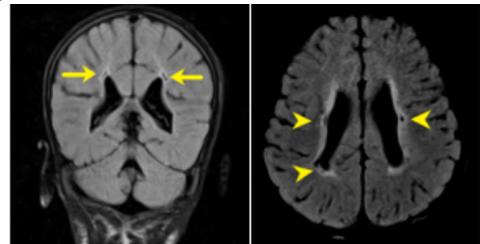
Coronal and axial FLAIR images of a 4yr old boy with complaints of seizures since 2 years and birth history of cord prolapse shows tiny periventricular cysts and prominent ventricles with irregular contour.
